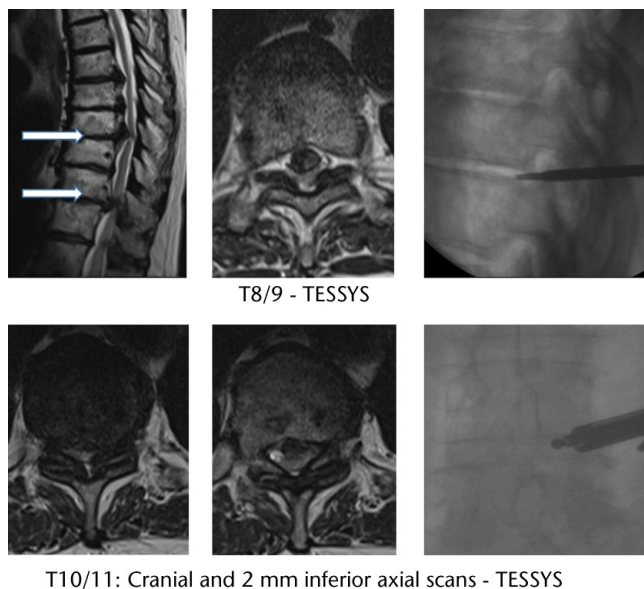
Severe central canal narrowing at T8/T9 and T10/11 with distortion of the spinal canal into a trefoil shape. Lateral image intensifier radiographs showing positioning of instruments (TESSYS, Transforminal Endoscopic Surgical System).
